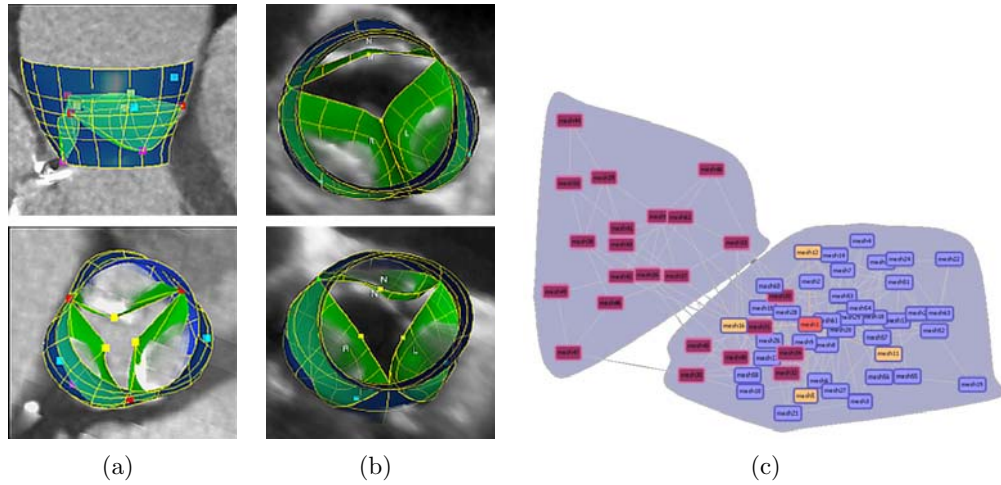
(a) Pathological aortic valves in CT: dilated aortic root and stenotic and calcified aortic valve. (b) Pathological aortic valves in TEE: bicuspid aortic valve and moderate stenotic valve. (c) Relative neighborhood graph with health (blue) and diseased (red) entries.
